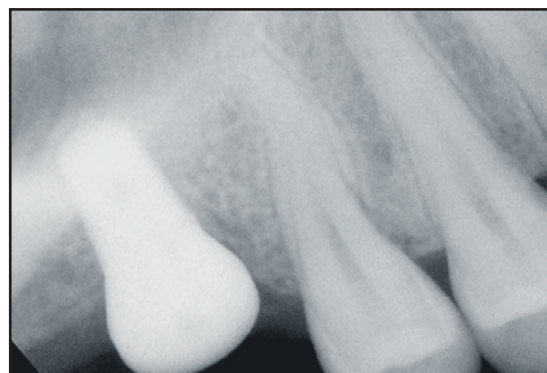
Immediate postoperative radiograph of 3 mm to 4 mm sinus elevation, which enabled the placement of a short implant using a single-stage protocol.
